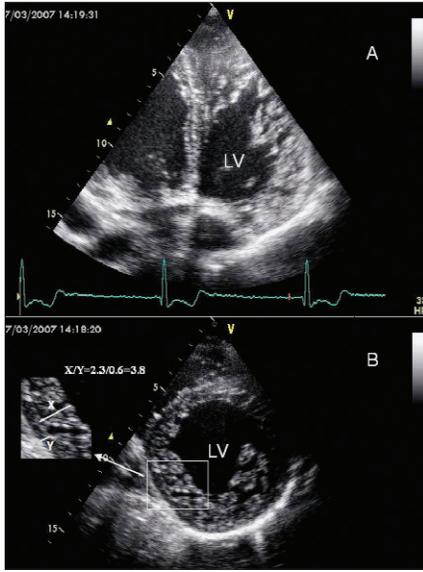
Left ventricular hypertrabeculation is detected in modified apical four-chamber view (upper panel). Ratio of noncompact to compact thickness is 3.8 in short axis view (lower panel)
